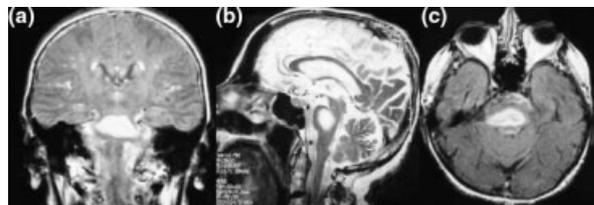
MRI scans showing in all three directions a large demyelinating lesion of the basis pontis (2×1.5×2.7 cm), respecting the pontine surface and partially affecting the cerebellar peduncles, with no contrast enhancement or perifocal oedema.
